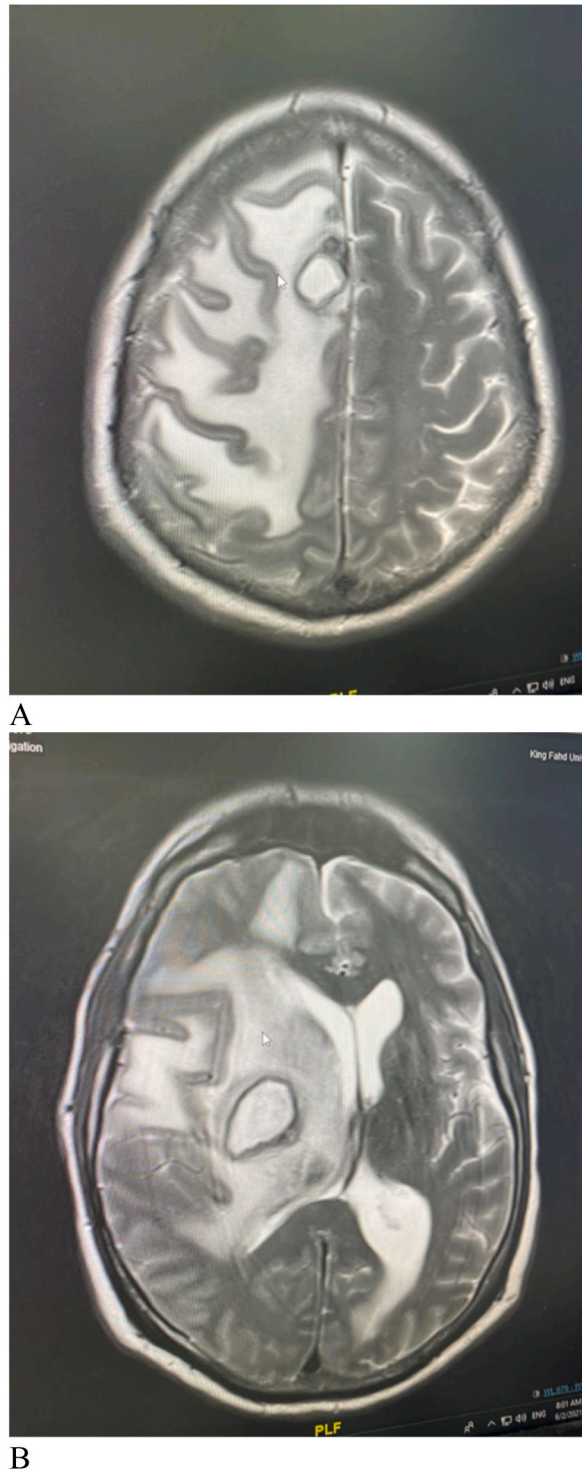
(A, B): Brain MRI. Three well defined lesions within the right basal ganglia and medial aspect of the right superior frontal gyrus, measuring: 10.8*1.8*1.4 cm and 0.7*0.8*0.5cm and 1.4*1.4*0.8cm in maximum diameter respectively which display hyperintense T2, hypointense T1 with diffusion restriction and peripheral nodular pattern of enhancement associated with extensive perifocal edema involving right frontotemporal parietal lobe.
